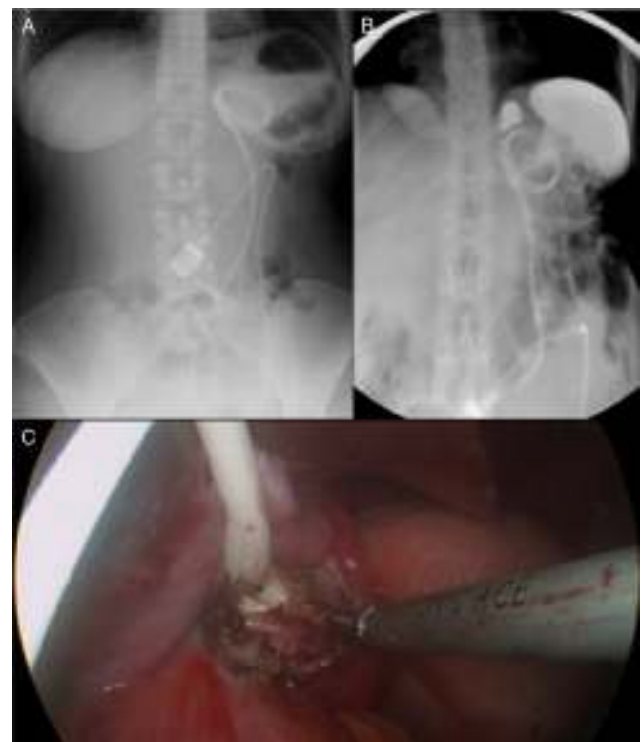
(A) Abdominal radiograph showing an enlarged gastric pouch with an air-fluid level and a dislodged gastric band with an abnormal angulation and annular appearance; (B) barium swallow depicting gastric band slippage with gastric pouch enlargement with retention of oral contrast; (C) laparoscopic image showing removal of the gastric band.
